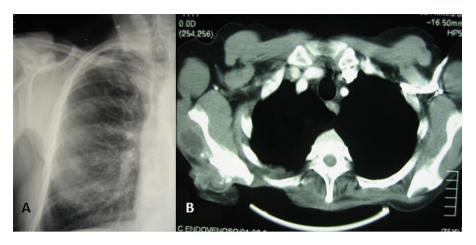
(A) Simple X-ray of the right shoulder. (B) CT scan that shows a tumor of chondral origin connected to the scapula.
